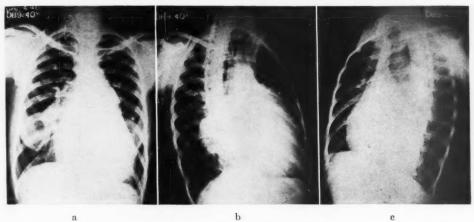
Roentgenograms of the patient with patent ductus arteriosus. (a) Postero-anterior view showing generalized cardiac enlargement and marked enlargement of the main pulmonary artery and its right branch. (b) Right anterior oblique view showing enlargement of the right ventricle and the left pulmonary artery. (c) Left anterior oblique view showing displacement or enlargement of the left ventricle.
